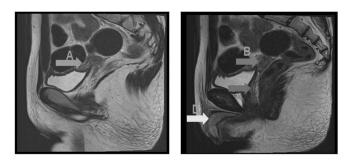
MRI of the lower abdomen (sagittal view)
